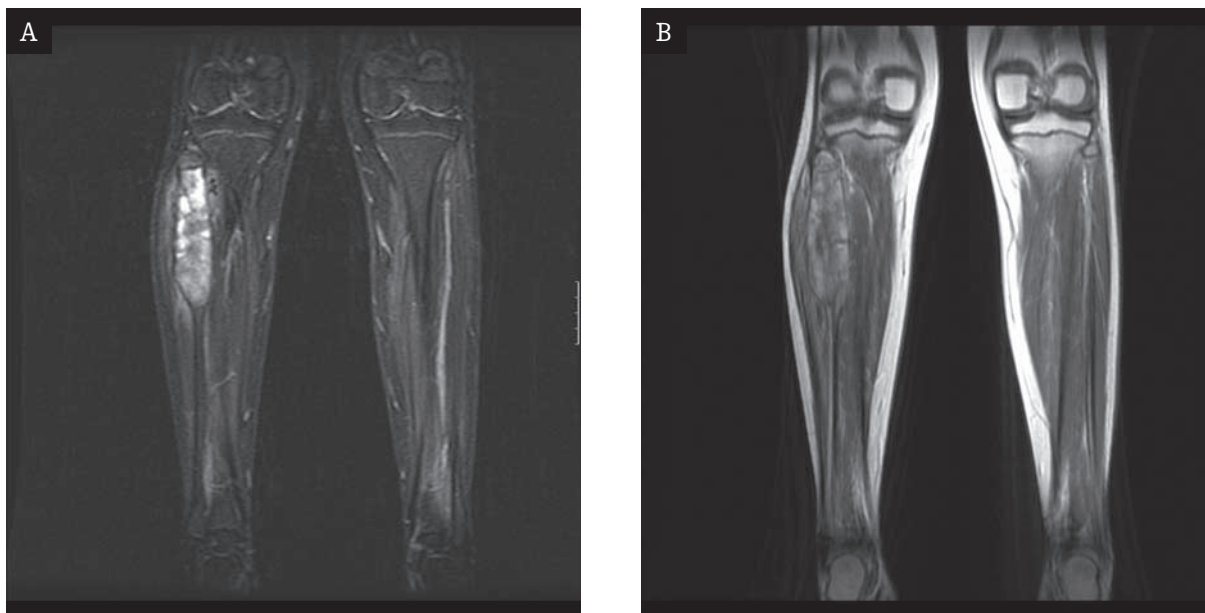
Ewing's sarcoma of the fibula. MRI during initial chemotherapy, coronal plane. A. STIR. Inhomogeneous tumor, infiltration of the medullary cavity does not exceed bony lesions. B. T1WI after Gd administration. Inhomogeneous contrast enhancement of the tumor; calcifications and areas of regression do not enhance.
